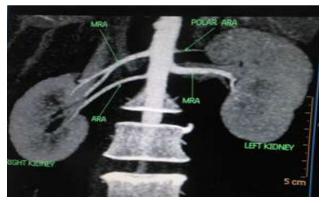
CT (MIP) Image Showing The Presence Of Single Accessory Renal Artery On The Right Side And One Single Accessory Renal Artery (polar Artery) Entering The Pole Of Left Kidney.
